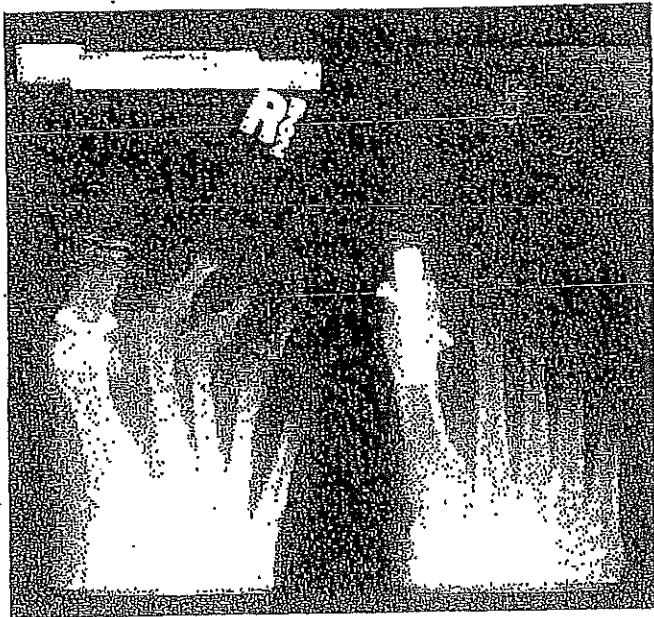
Radiographic examples of the two fixation methods tested during this study. These represent actual postoperative patient radiographs, not study trials. *Left*, two crossed screws. *Right*, six-hole dorsal plate with a single interfragmentary screw.
